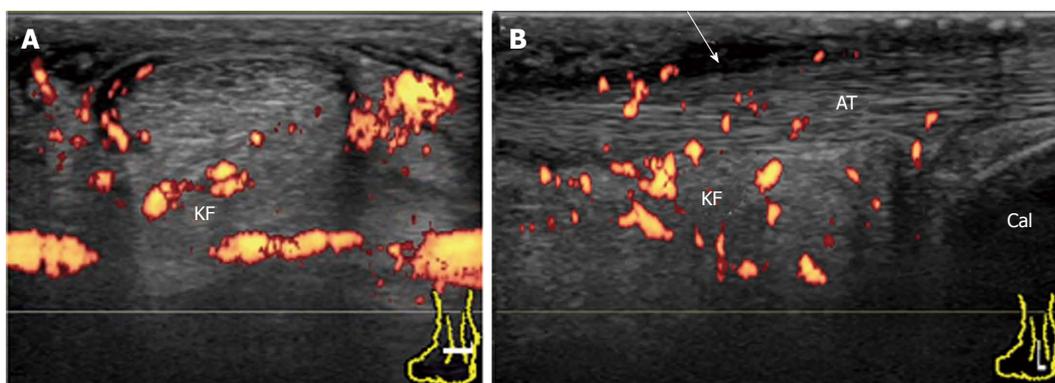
Achilles paratenonitis in early rheumatoid arthritis. Transverse (A) and longitudinal (B) power Doppler sonogram of the AT shows thickened, hypoechoic, and hyperemic paratenon (arrow) at the level of the KF with minimal tendinopathy. Hyperemia in the KF is also depicted. AT: Achilles tendon; KF: Kager's fat pad; Cal: Calcaneus.
